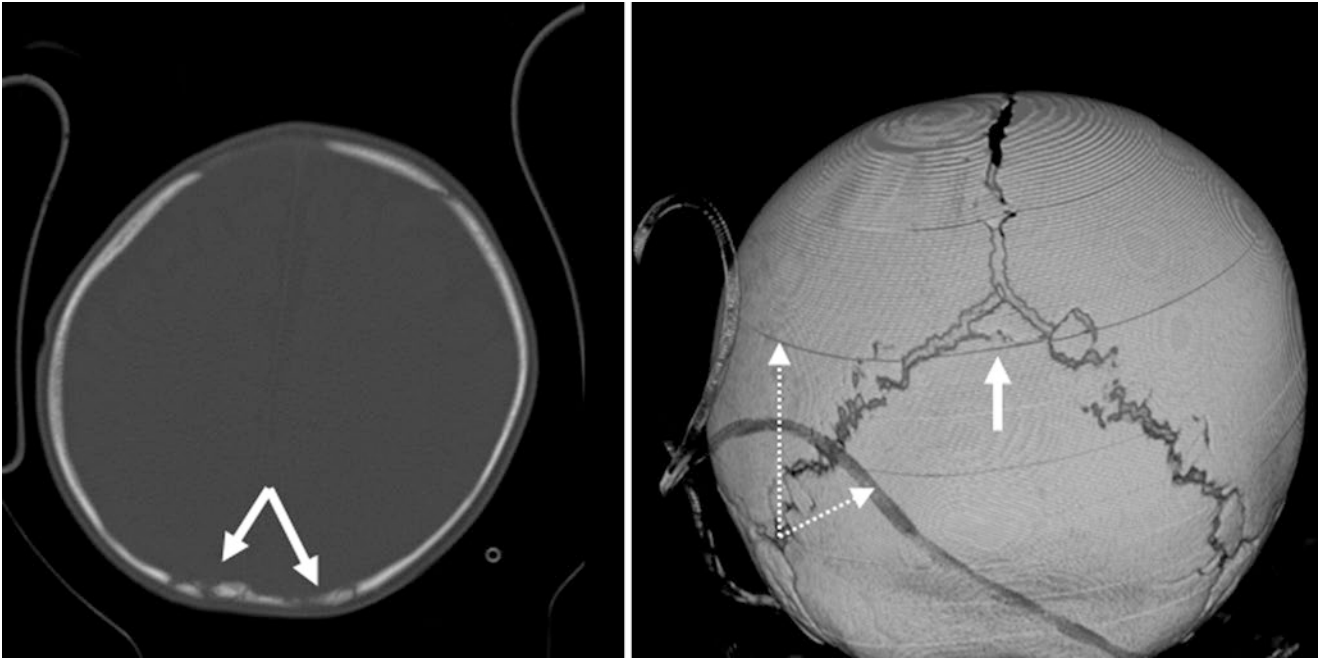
A 7 month old with an irregular bone within the PF as well as other intrasutural bones on axial NECT (*left*) and 3D VR CT posteroanterior view (*right*). Note the motion artifact (*dotted arrows*)
